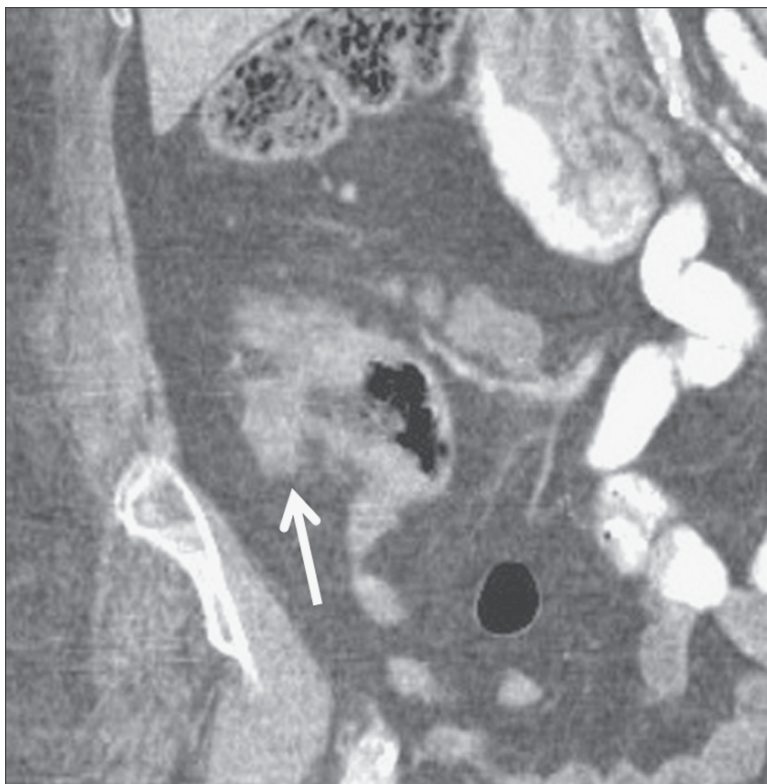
Coronal CT reformation of axial CT data demonstrates a soft tissue mass in the wall of the cecum (arrow). Note the irregular, serrated outer contours of the mass with strands of soft tissue, indicating transmural spread of tumor, which was confirmed at laparotomy
